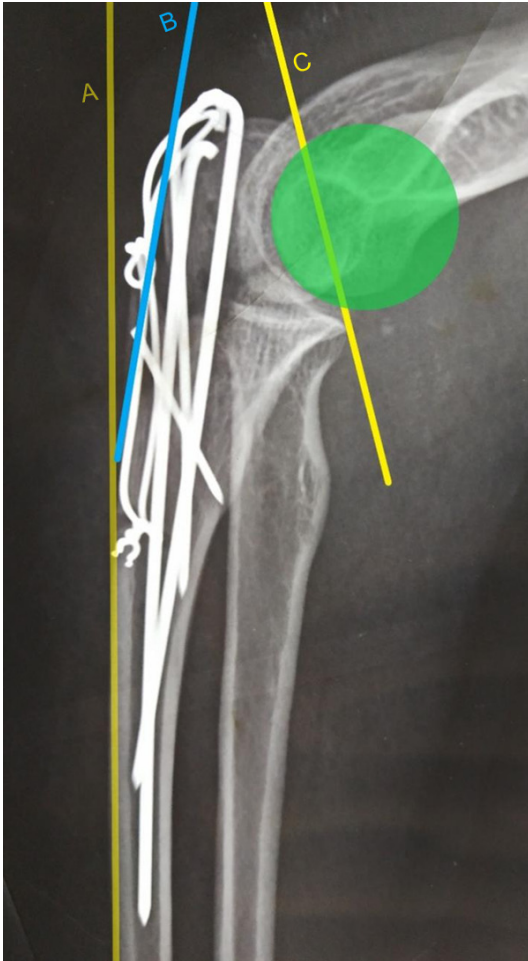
Case 6-anteroposterior and lateral radiograph of the elbow at the final followup showing reduced elbow with united olecranon fracture.
